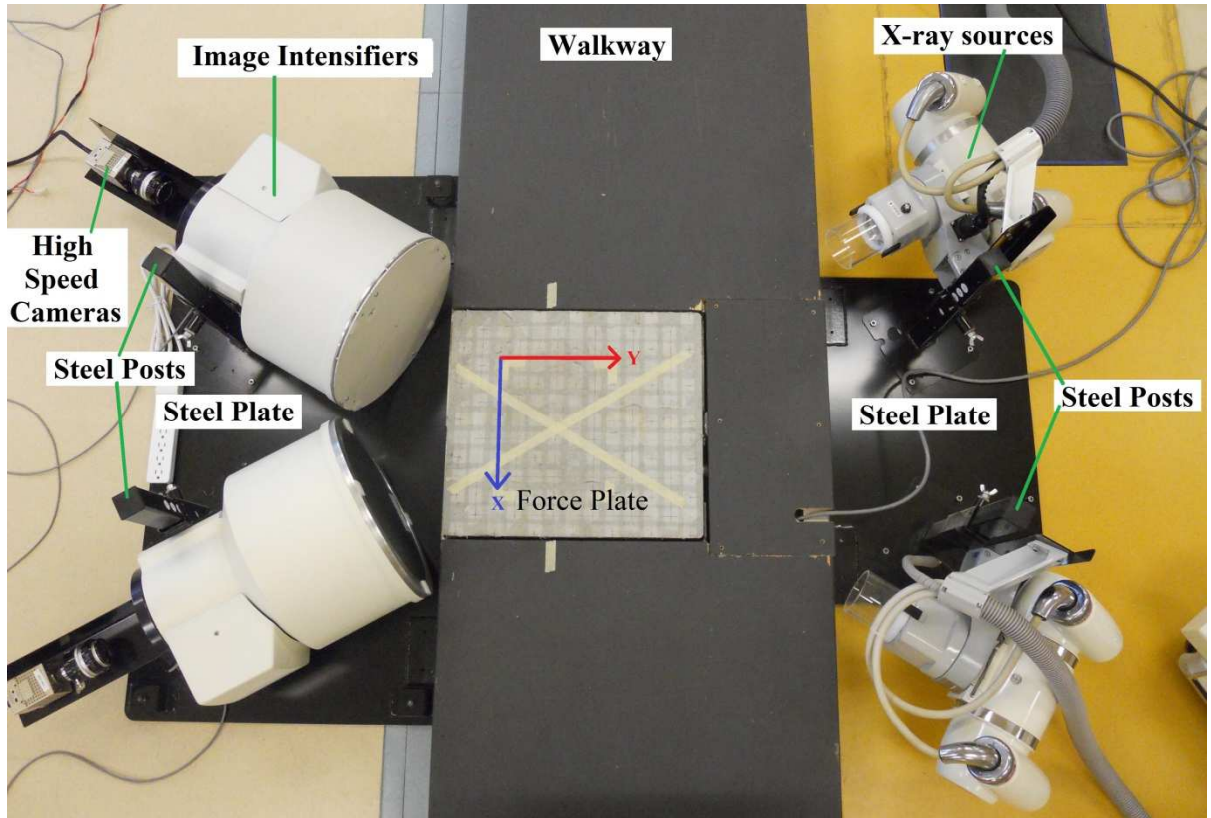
Custom-built biplane fluoroscopy system with x-ray sources attached to right-hand side of walkway and image intensifiers attached to left-hand side. The embedded force plate is placed where x-ray beams intersect. Global lab coordinate system shown with x-axis parallel to the walkway, y-axis across the walkway, and z-axis perpendicular to the walkway (z-axis not shown).
